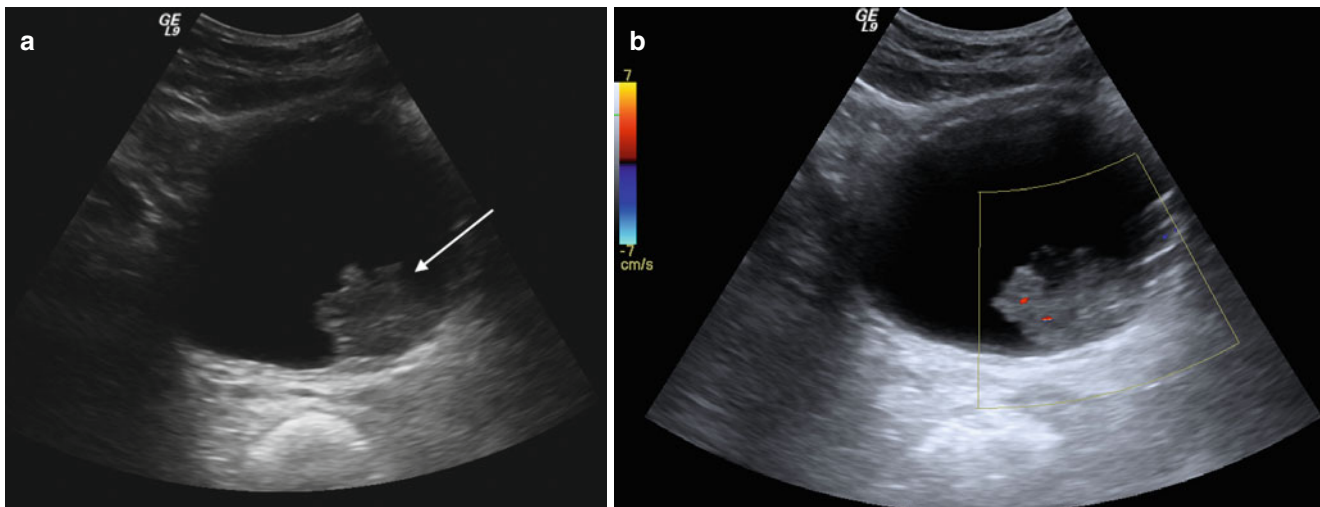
Urinary bladder neoplasm. Transverse gray-scale (a) and color Doppler (b) sonographic images of the urinary bladder demonstrate a solid, exophytic mass within the urinary bladder lumen (arrow
